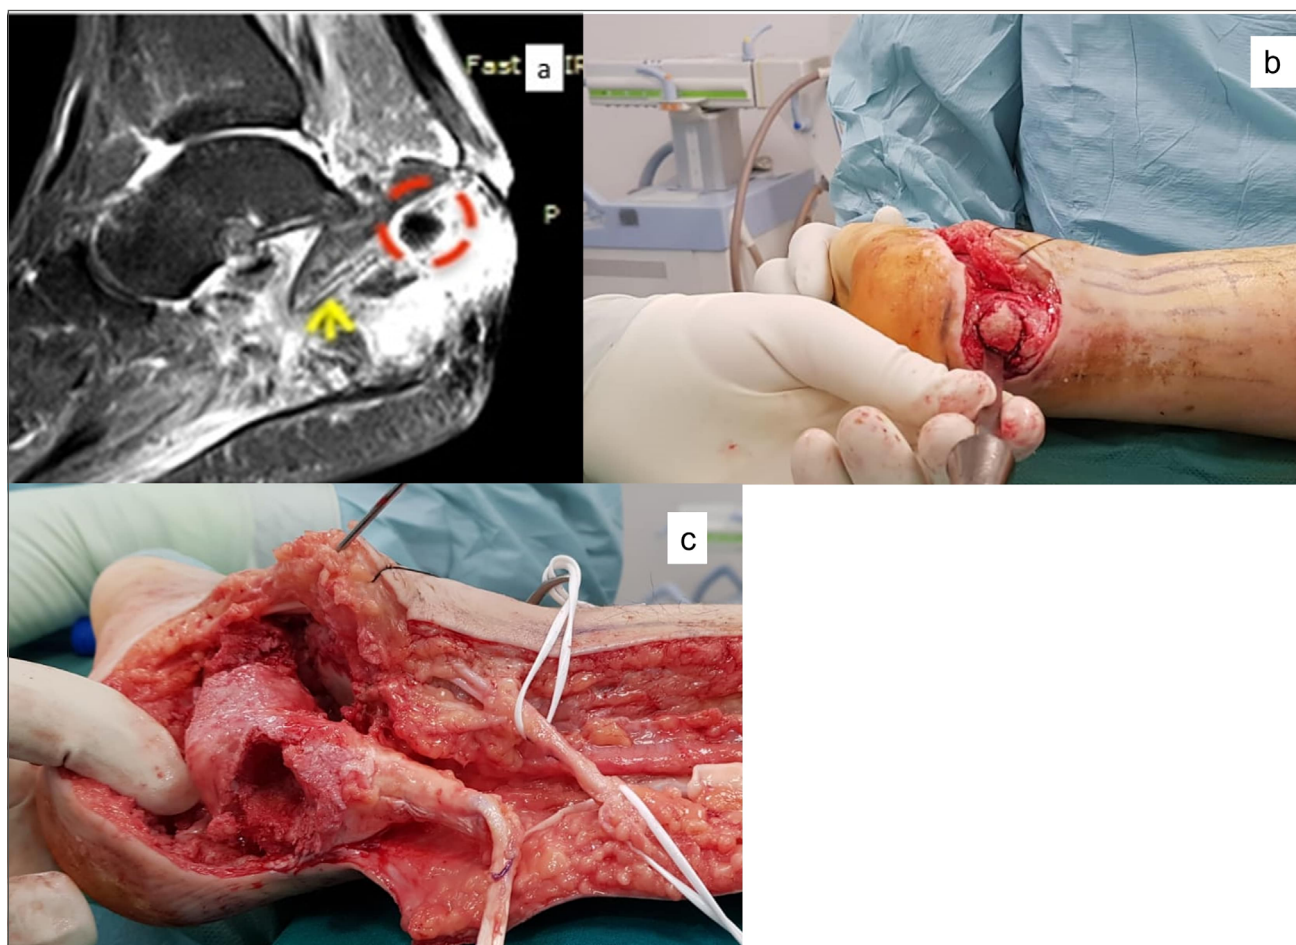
A) MRI pre-operative planning that shows osteomyelitis of the posterior pole of the calcaneus; B-C) En-bloc excision with macroscopic clear margins of the osteomyelitic bone.
